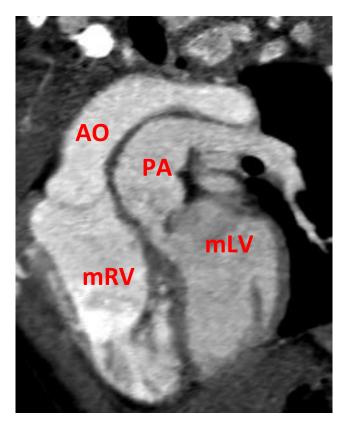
CT image shows D-TGA has aorta arising from morphological right ventricle (m RV) and The aortic root locates anterior and rightward of the pulmonary trunk (PA), which is designated as "{_,_,D-TGA}".
